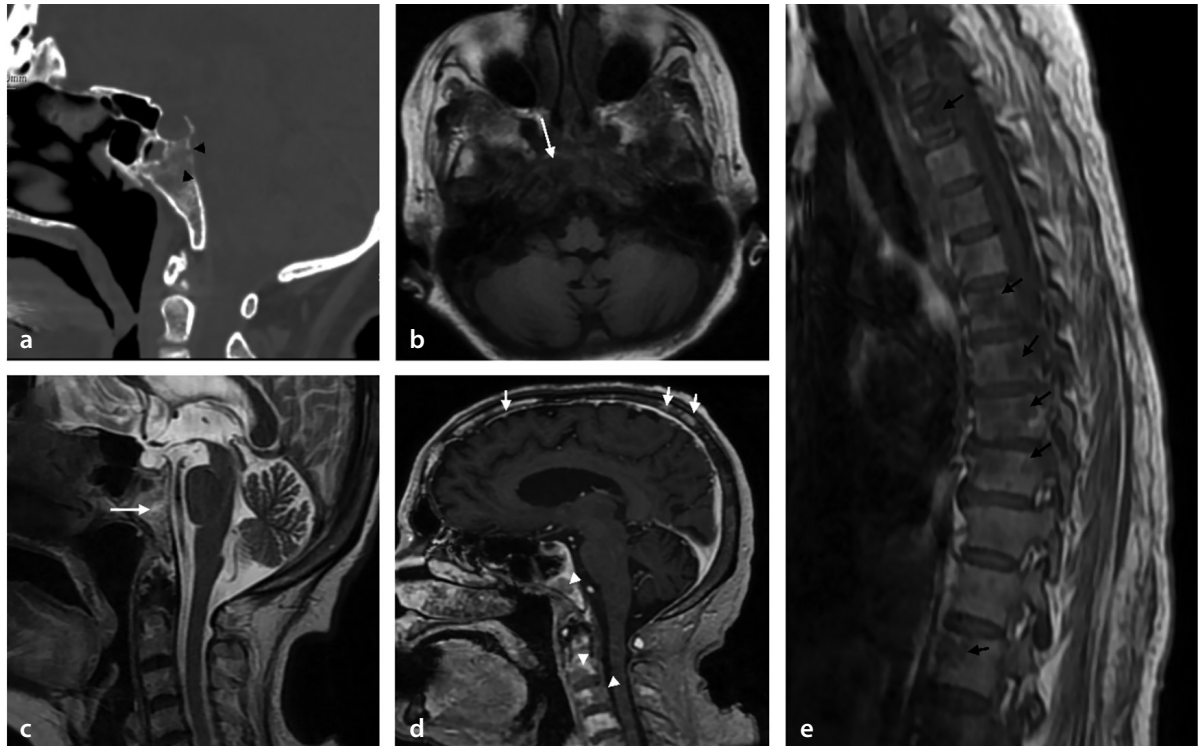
A 71-year-old female patient diagnosed with multiple myeloma. Computed tomography scan (a) reveals a lytic, destructive lesion in the clivus (black arrowhead). Axial T1-weighted (T1W) magnetic resonance imaging (MRI) (b) reveals the lesion as hypointense, whereas the sagittal T2-weighted MRI (c) demonstrates it as hyperintense (long white arrow). Post-contrast sagittal T1W MRI (d) reveals multiple lesions in the calvarium (short white arrows), clivus, and cervical vertebrae (white arrowheads). Sagittal T1W thoracic MRI (e) reveals diffuse bone marrow signal reduction with multiple focal hypointense lesions (black arrows). The combination of focal lesions within a diffuse pattern, along with bone marrow involvement, older age, and clinical-laboratory findings, supports the diagnosis of multiple myeloma.
